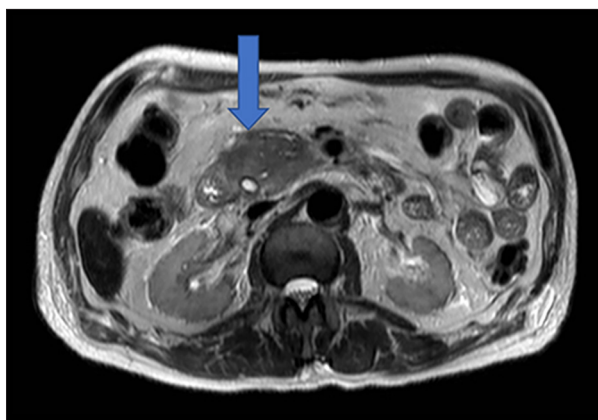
Computed Tomography (CT) scan demonstrating pancreatitis (arrow) with small cyst.
